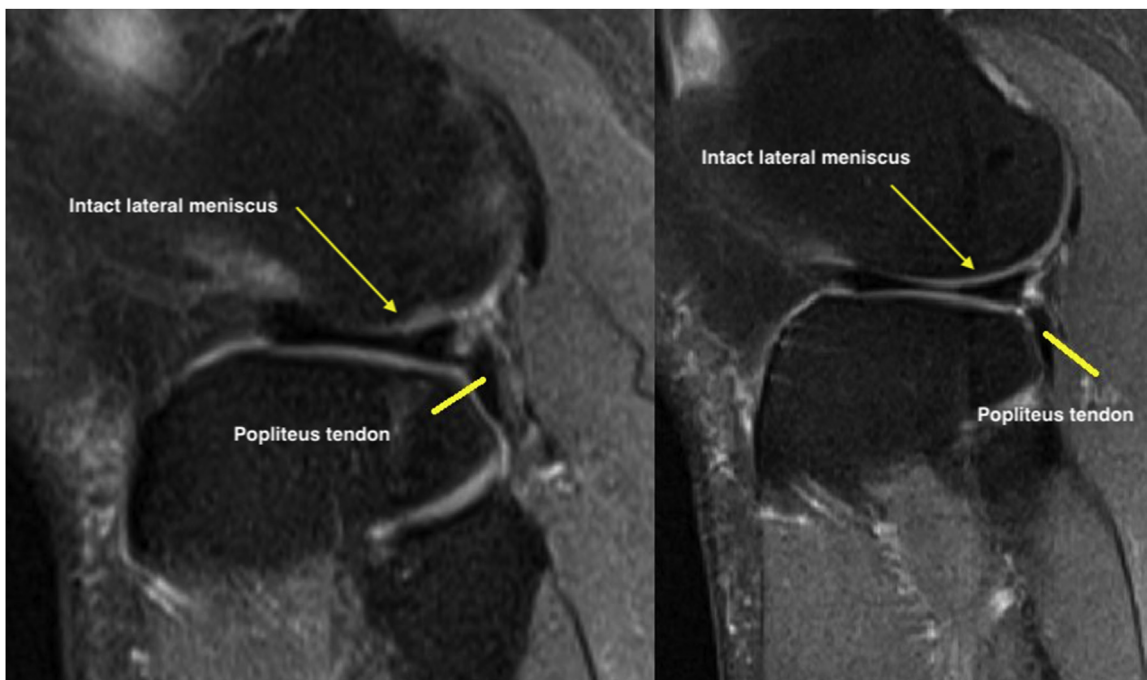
Sagittal T2 MRI cuts showing Normal MRI anatomy.
